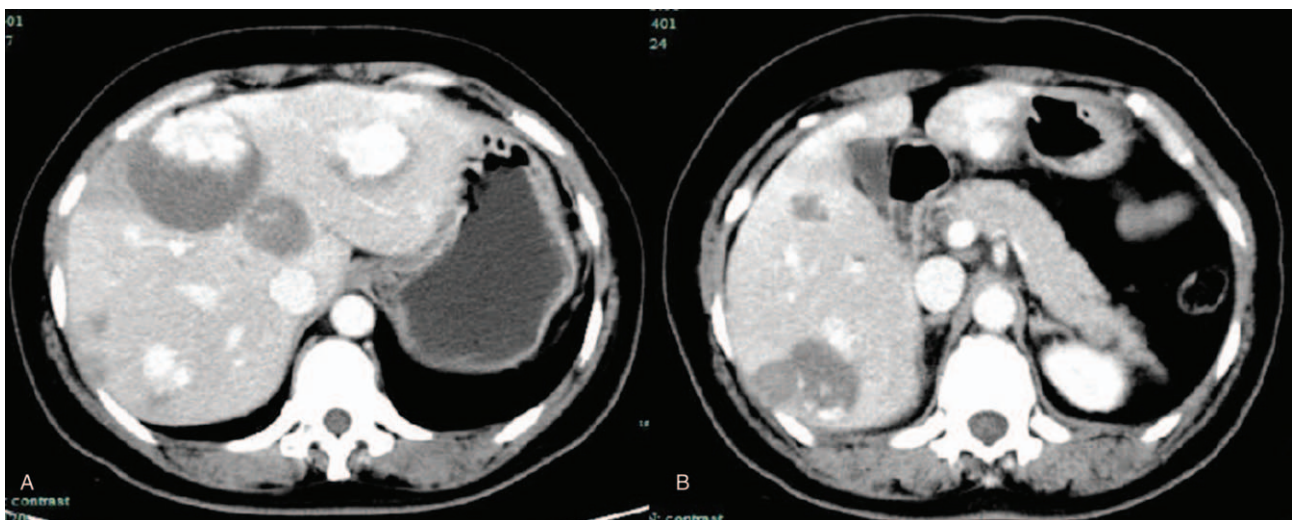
CT scan demonstrating for multiple hepatic mass after 3 years of splenectomy. CT=computed tomography.
